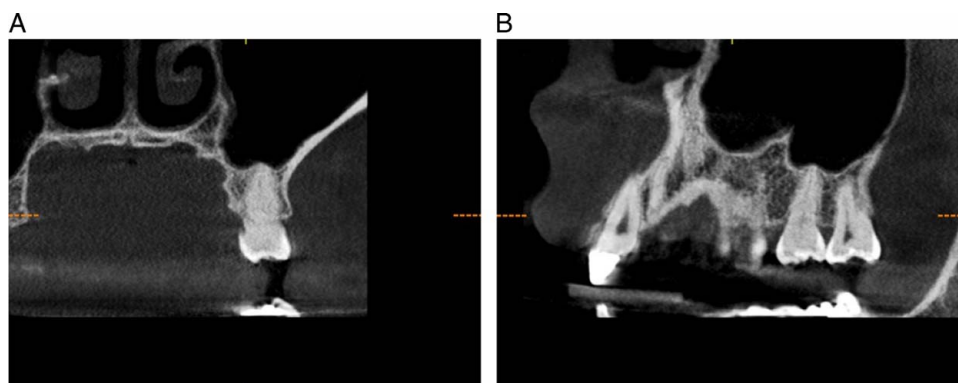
(A) Cone beam computed tomography: recall after 15 years (sagittal view). (B) Cone beam computed tomography: recall after 15 years (vestibular view).
